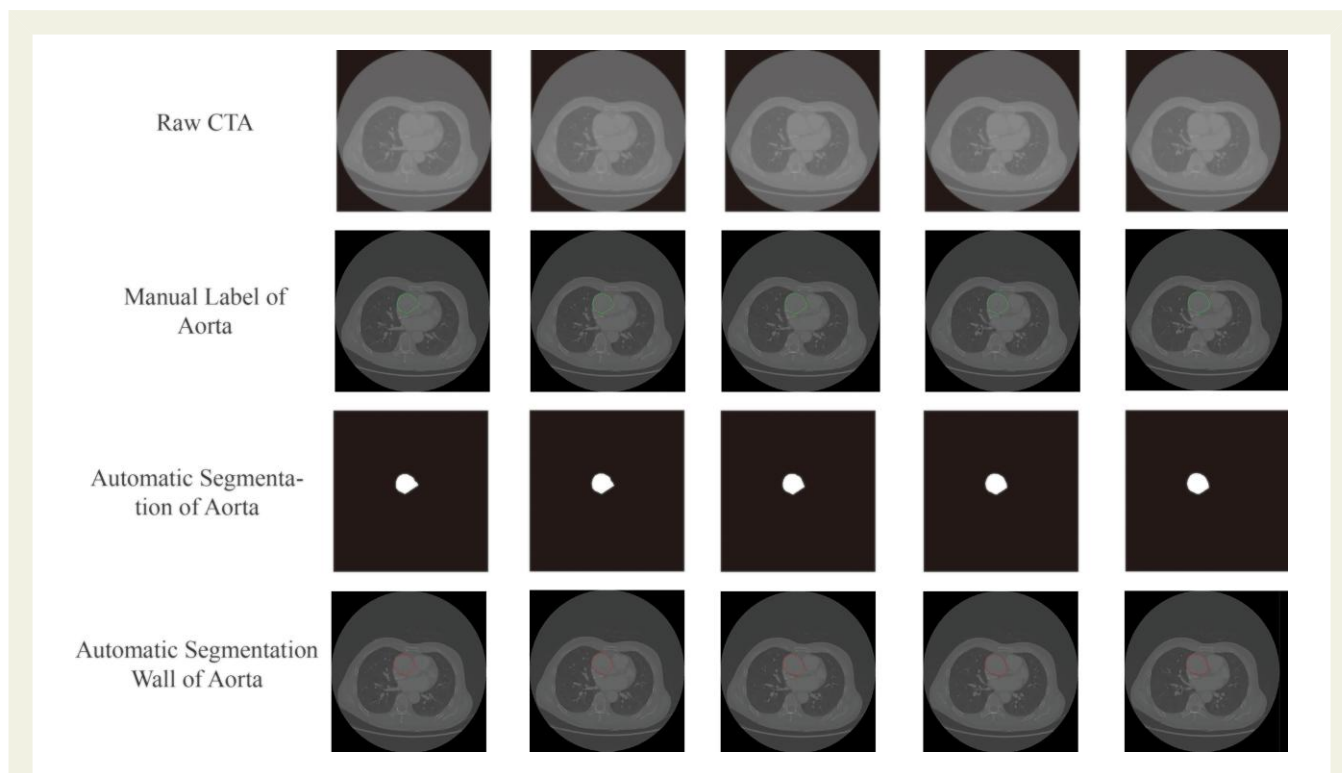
The results of ascending aorta automatic segmentation. The first line shows the raw computed tomography angiography of ascending aorta, and we manually labelled the wall of aorta (the second line). After training, the mask of aorta (the third line) and the aortic wall (the last line) can be extracted automatically. CTAs, computed tomography angiographies.
